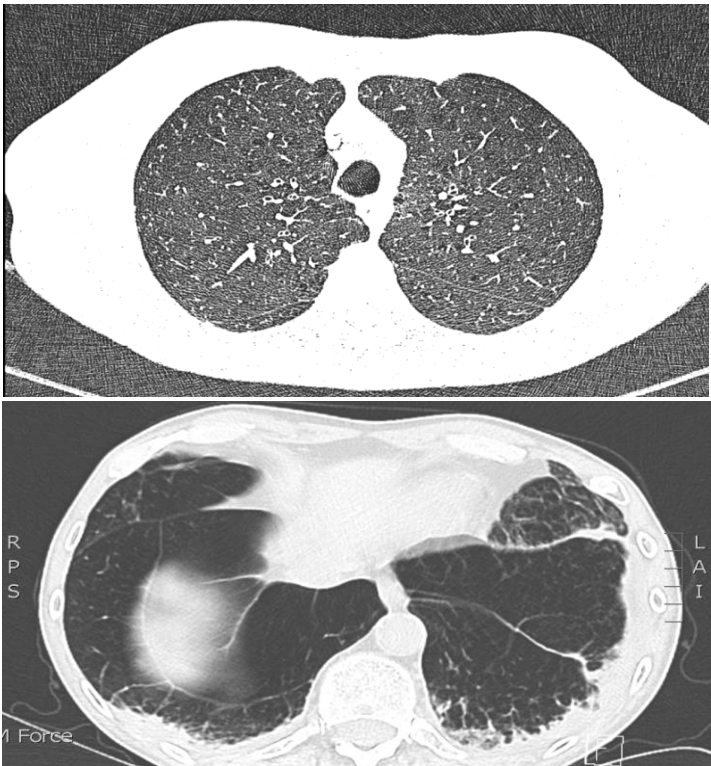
Representative axial non-contrast CT image. Areas of severe centrilobular and paraseptal emphysema are identified by focal regions of low attenuation without visible walls. Concurrent basal subpleural reticulation is present, seen as linear opacities parallel to the pleural surface. The juxtaposition of emphysema and basal fibrotic change demonstrates the characteristic imaging phenotype of CPFE.
